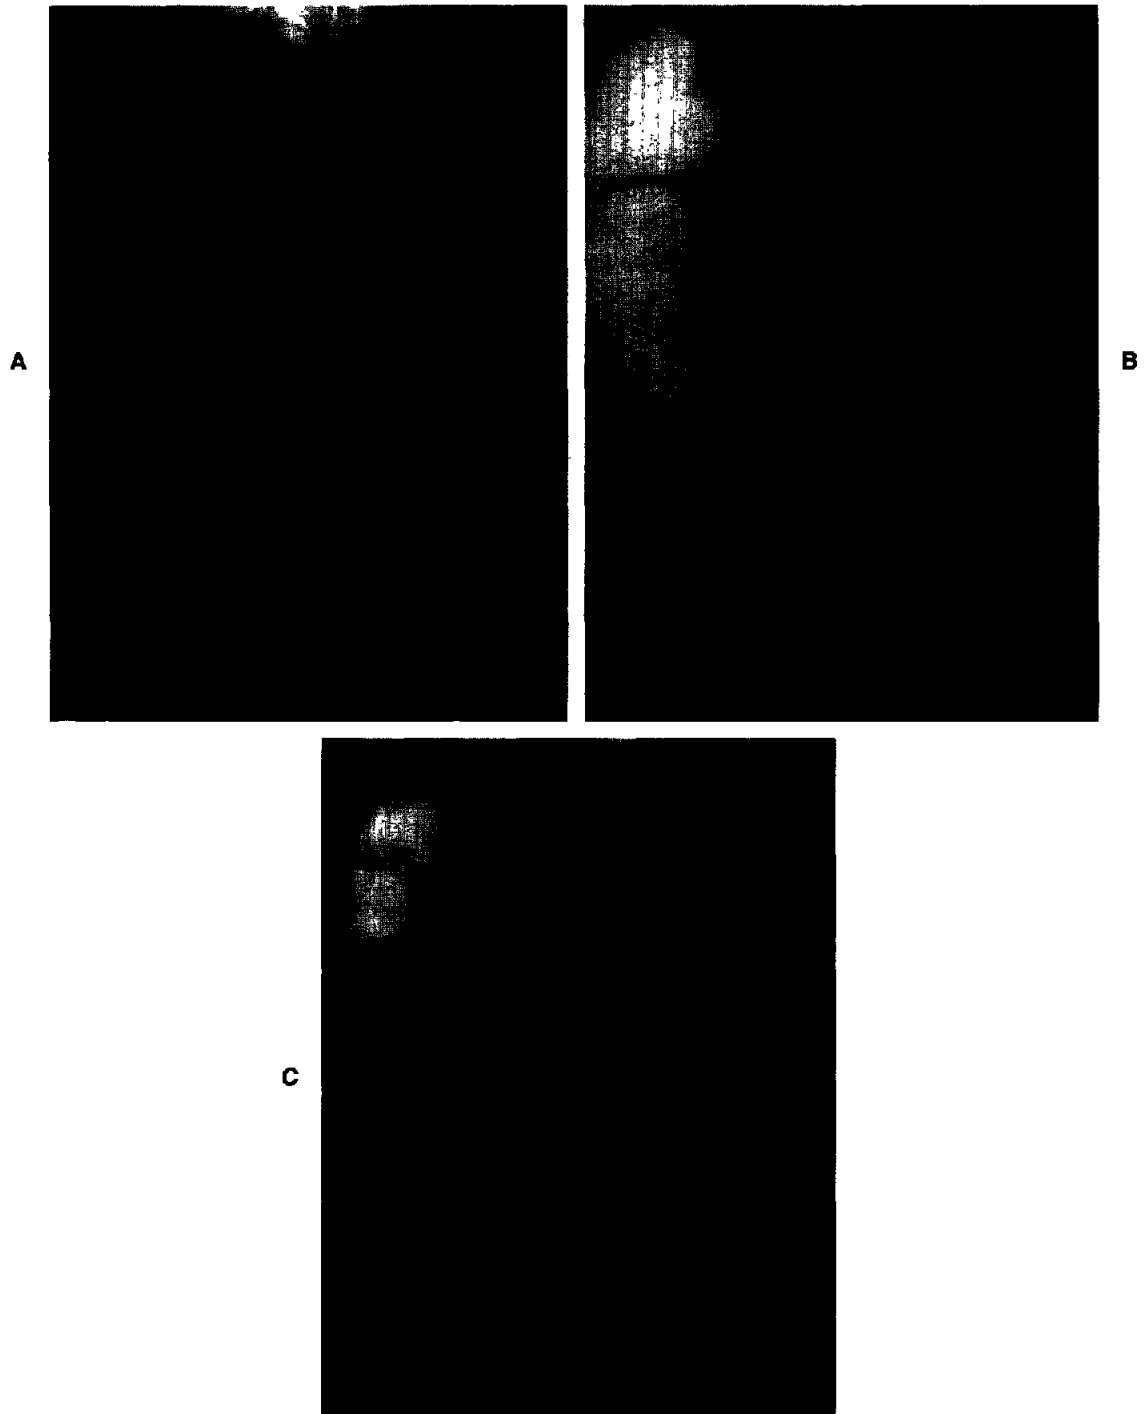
Photographs of (A) pre-enema abdominal x-ray film, (B) immediate postenema x-ray film, and (C) 12-hour postenema x-ray film.
